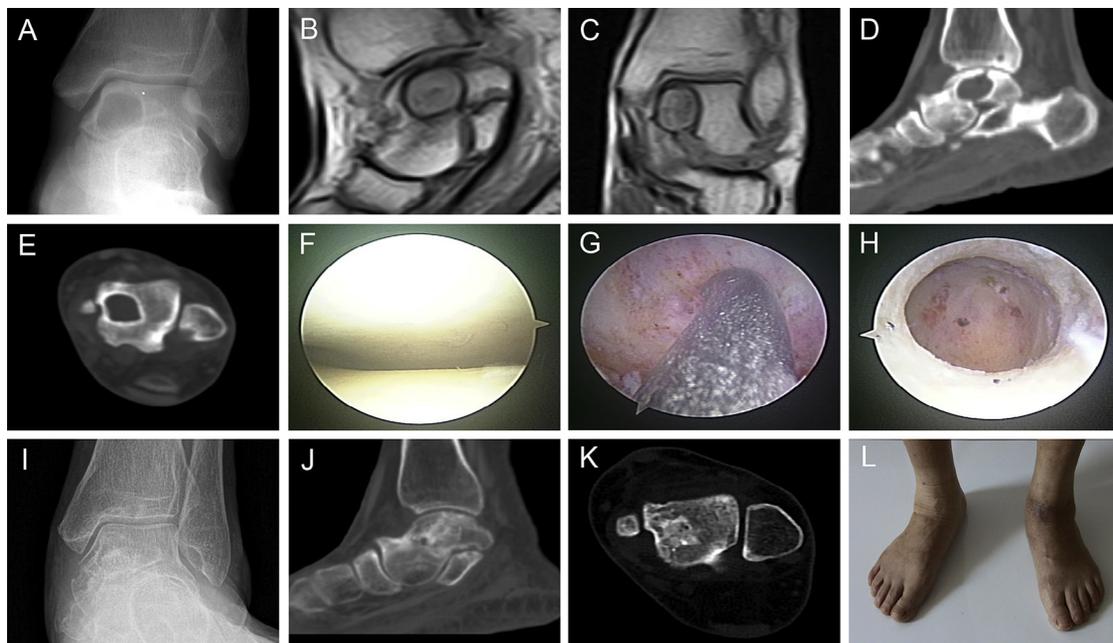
Typical case 1: 59-year-old female, with a diagnosis of a talar cyst in the left extremity. The preoperative examinations included (A) radiography, (B,C) magnetic resonance imaging examination, and (D,E) computed tomography evaluation. Intraoperative images showing (F) integrity of articular cartilage, (G) removal of the lesion tissue with curettage, and (H) the drilled defect before bone grafting. The 1-year postoperative examinations included (I) radiography and (J,K) computed tomography. (L) View showing performance of the left ankle without swelling or pain.
